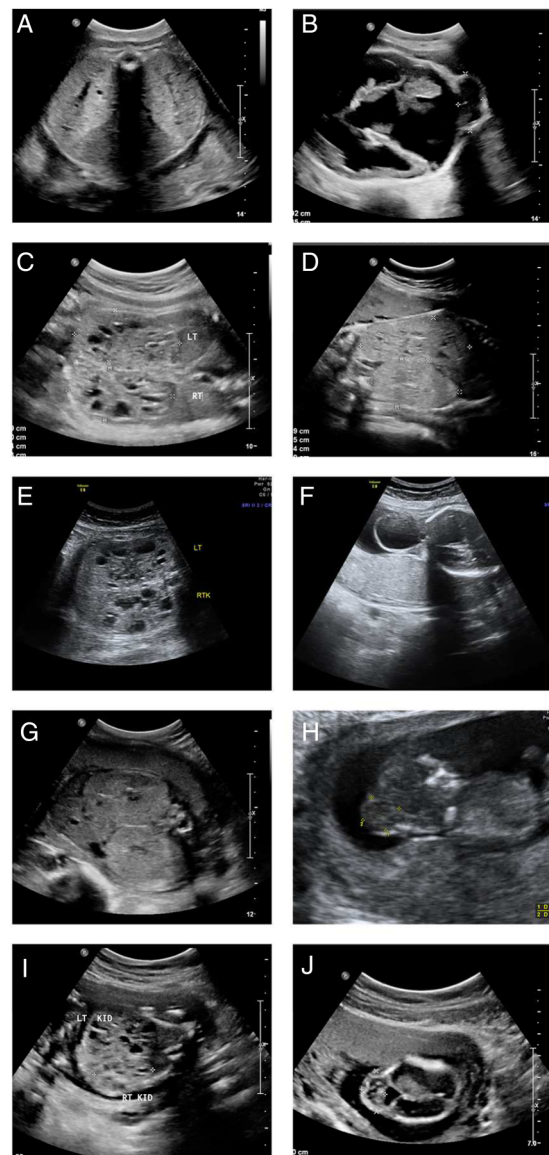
Prenatal ultrasound images of affected fetuses. (A and B) FT-8: transverse view of the fetal abdomen at 33 weeks of gestation (A), showing enlarged echogenic kidneys. Transverse view of the fetal head at 33 weeks of gestation (B), showing a cystic mass arising from the occipital area of the fetal head representing an encephalocele. (Genotype: *CC2D2A* homozygous mutation.) (C) FT-10: a transverse view of the fetal abdomen at 23 weeks of gestation, showing enlarged echogenic kidneys with cystic areas. (Genotype: *TMEM67* homozygous mutation.) (D) FT-20: a transverse view of the fetal kidneys at 33 weeks, showing enlarged echogenic kidneys. (Genotype: *TCTN2* homozygous mutation.) (E and F) FT-1: a transverse view of the fetal kidneys at 31 weeks of gestation (E), showing enlarged echogenic cystic kidneys. A transverse view of the fetal head at 31 weeks of gestation (F), showing a cystic mass arising from the fetal occiput, which represents an encephalocele. (Genotype: *CC2D2A* homozygous mutation.) (G) FT-9: a transverse view of the fetal abdomen at 27 weeks of gestation showing bilateral enlarged echogenic kidneys. (Genotype: *INVS* homozygous mutation.) (H) FT-13: a sagittal view of a fetus at 12 weeks of gestation showing a mass arising from the posterior aspect of the fetal head, which represents an encephalocele. (Genotype: *MKS1* homozygous mutation.) (I) FT-22: a transverse view of the fetal abdomen at 18 weeks, showing enlarged kidneys with cystic changes. (Genotype: *TMEM67* homozygous mutation.) (J) FT-21: a transverse view of the fetal head at 16 weeks of gestation, showing a mass arising from the posterior aspect of the fetal head, which represents an encephalocele. (Genotype: *CC2D2A* homozygous allele.)
